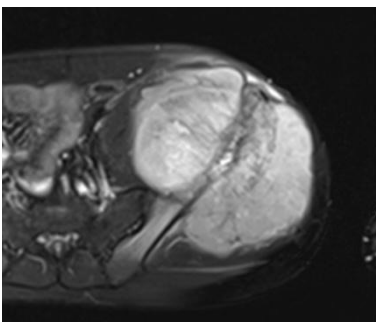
T1W1 20 year old boy proven case of desmoplastic fibroma, a rare tumor with cortical destruction. Soft tissue extension, which is commonly seen. X-ray shows lytic areas also in right femur, pelvic bone (arrow), sacrum(not shown)
